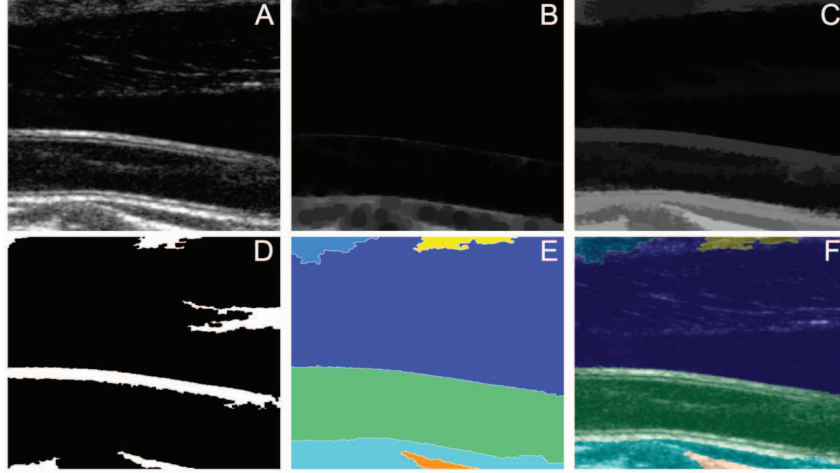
Representation of the watershed-based segmentation for CCA ultrasound images. The original image (A) is first eroded by using a disk-shaped structuring element (B) and then reconstructed against the original image (C). The reconstructed image is thresholded and the above-threshold regions correspond to the markers (D). Fig. E reports the color-coded watershed segmentation. Fig. F reports the watershed basins overlaid to the original image.
